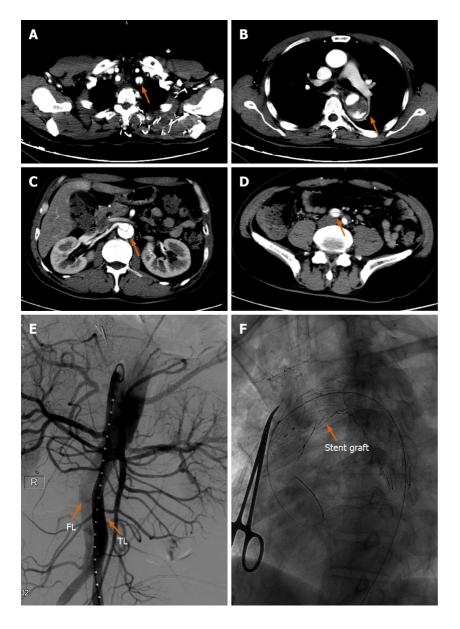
Computed tomography angiography. A: Computed tomography angiography of the aorta on hospital day 9 showed an aortic dissection involving the left subclavian artery; B and C: Descending aorta; D: Extending to iliac artery; E: Aortic angiography during thoracic endovascular aortic repair surgery showing false lumen and true lumen (orange arrow); F: Stent graft was implanted into the vascular (orange arrow). FL: False lumen; TL: True lumen.
